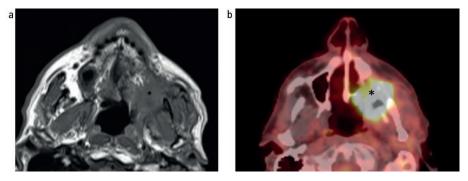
Recurrent oral cavity tumour. (a) Axial T1-weighted MRI image shows intermediate signal soft-tissue lesion at the left retromolar trigone and pterygomandibular raphe in keeping with recurrent disease (*). This demonstrates significant uptake of tracer on the PET-CT scan (b)
